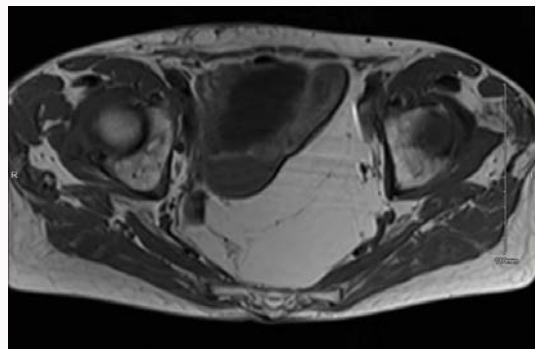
Axial view of pelvic lipoma on MRI.
